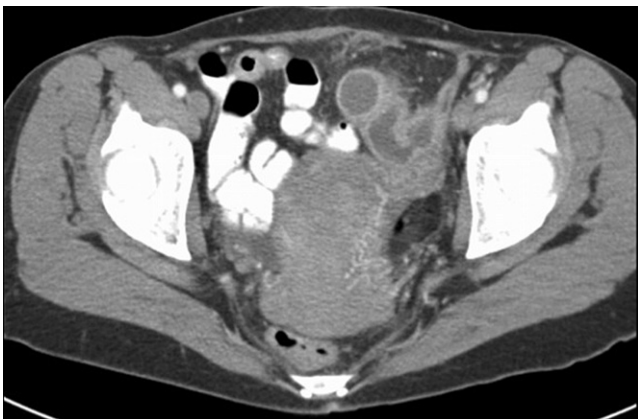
Unilateral pyosalpinx in a 50-year-old patient with left lower quadrant pain and fever. Axial contrast-enhanced computed tomography, revealing a dilated, fluid-filled left fallopian tube with a thickened and enhancing wall. There are inflammatory changes of the adjacent fat.
